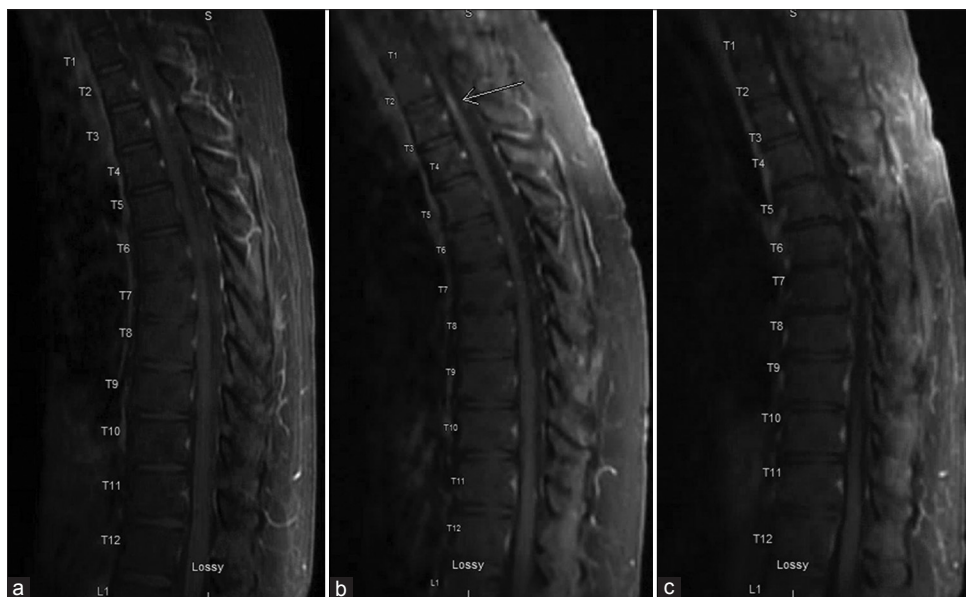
Follow up serial sagittal T1-weighted magnetic resonance imaging of the thoracic spine with contrast – 3 months (a), 6 months (b), and 10 months (c) from initial imaging [Figure 2c] – demonstrate interval regression and ultimate resolution of the enhancing intramedullary spinal cord lesion.
